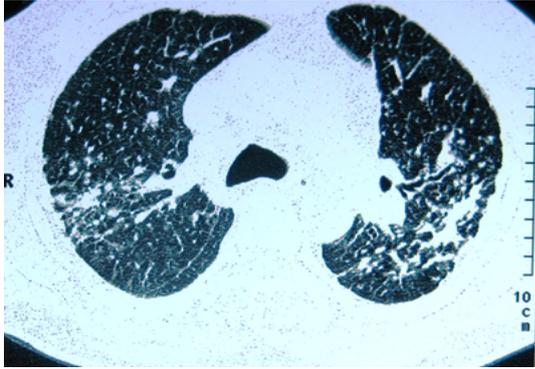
Number 2 technician's pneumoconiosis diagnosed HRCT.
